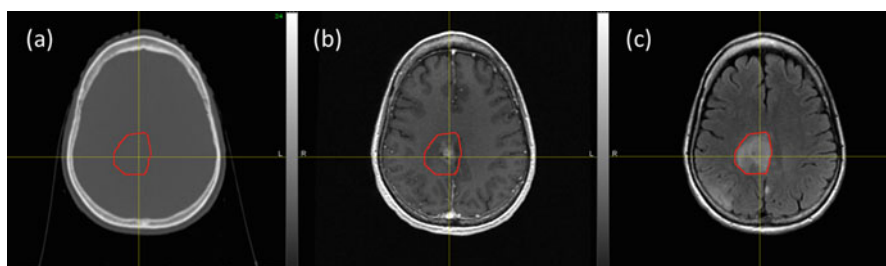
(a) A brain tumor outlined by the red contour on CT image is indiscernible to the surrounding normal tissue, while (b) the lesion is clearly visible on T_1 -weighted MRI image, and (c) edema surrounding the tumor is highlighted on the T_2 -weighted MRI image
